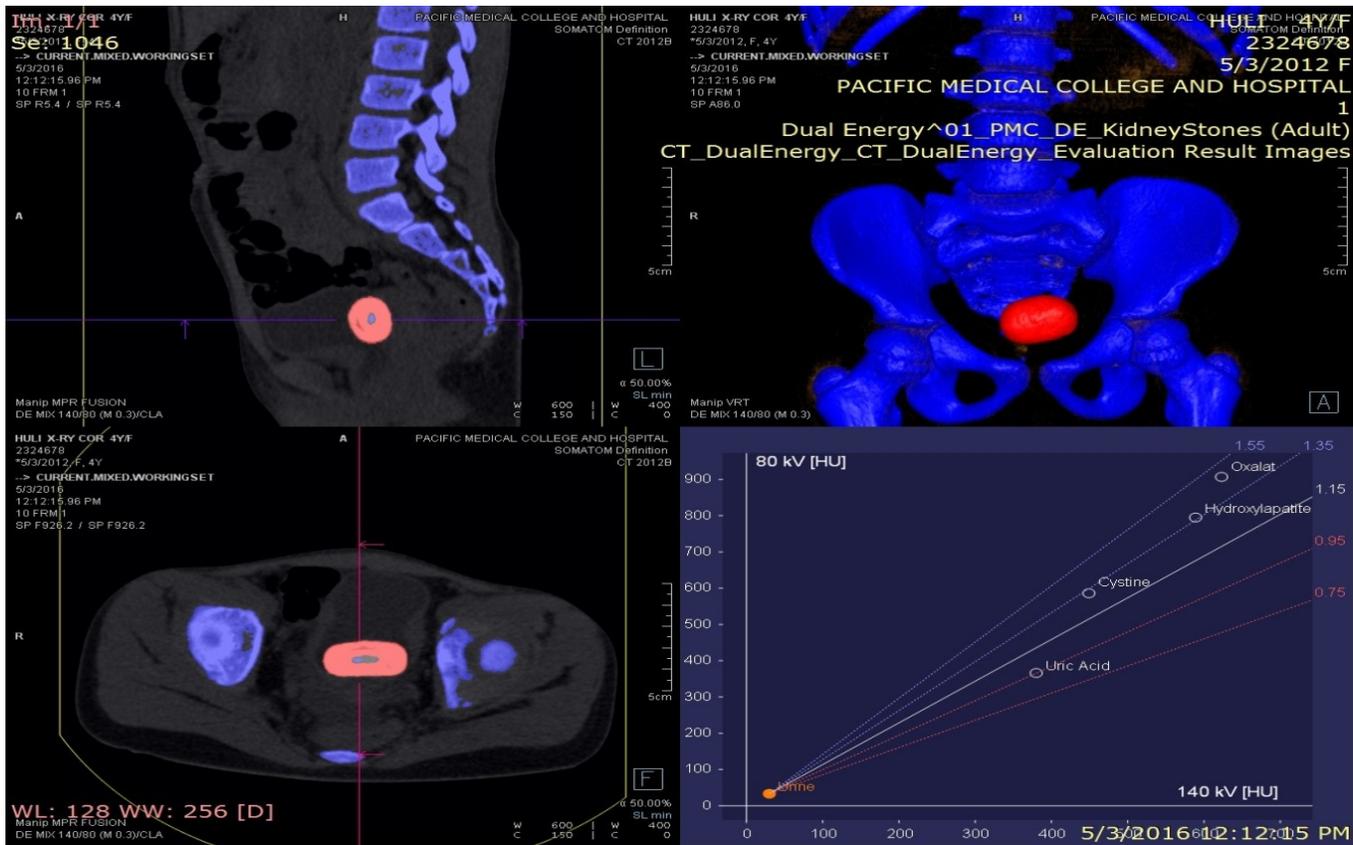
Elaborated images with calculi characterization software by siemens, including three views of stone in sagittal, axial planes and 3D in coronal plane with graphic presentation. This is the case of 4 year female child having a large urinary bladder calculus of 29mm with average CT density of 527 HU. The calculus in three views is automatically painted red by software as its CT density and attenuation ratios lies in lower part of graph. These software findings are suggestive of uric acid stone.
